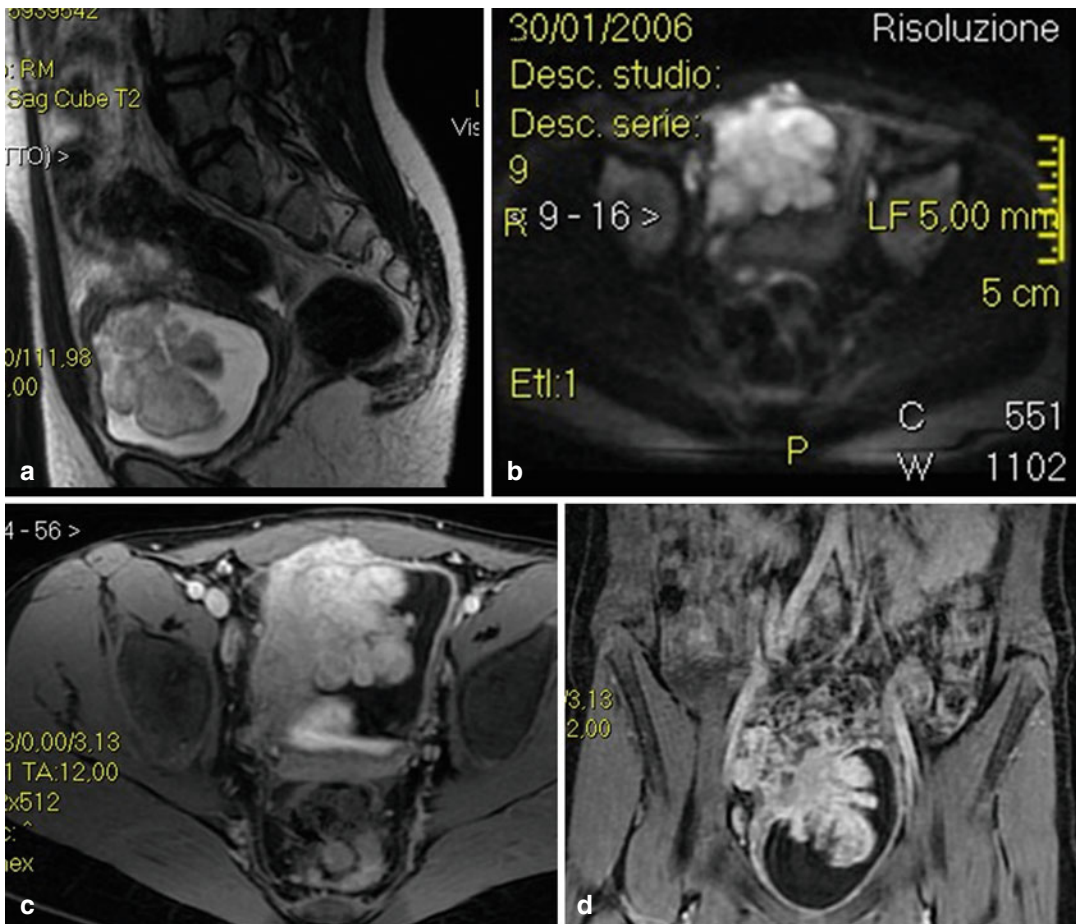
Bladder rhabdomyosarcoma on MR images. Sagittal T2w scan (a) shows a isointense mass protruding into the bladder lumen; axial DWI image with b value of 600 (b) shows a restricted diffusion of the mass which
